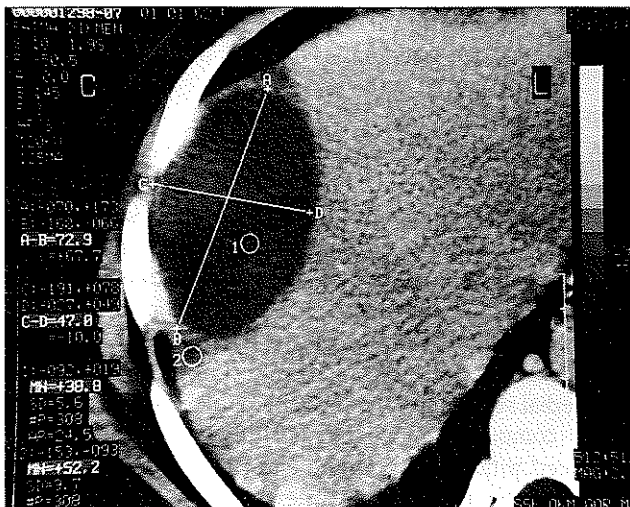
The control CT view of patient, 3 months after trauma. An organized hematoma in the right lobe of the liver could be seen.
